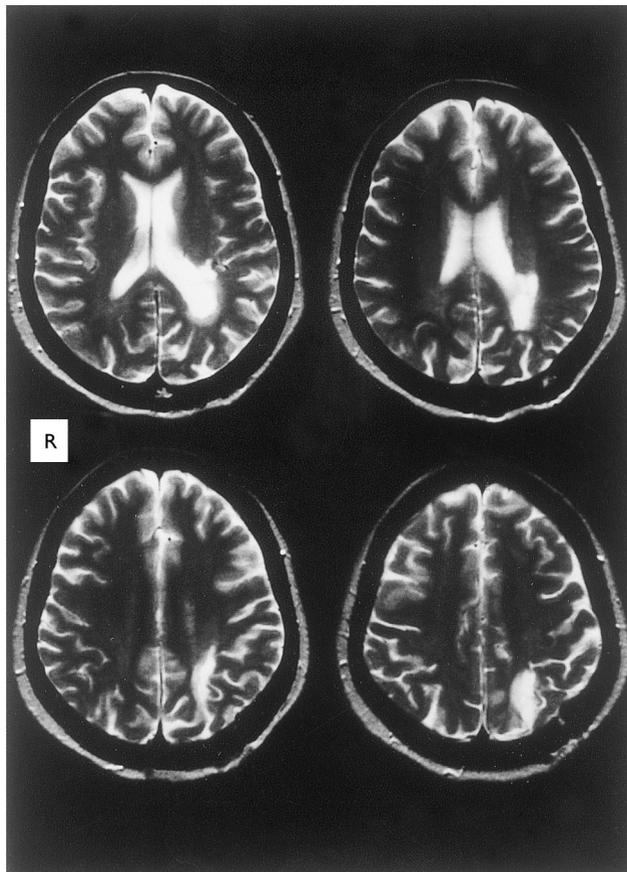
MRI scan 6 months after surgery showing tumor scar in the cortical and subcortical white matter of the left upper parietal lobule.
